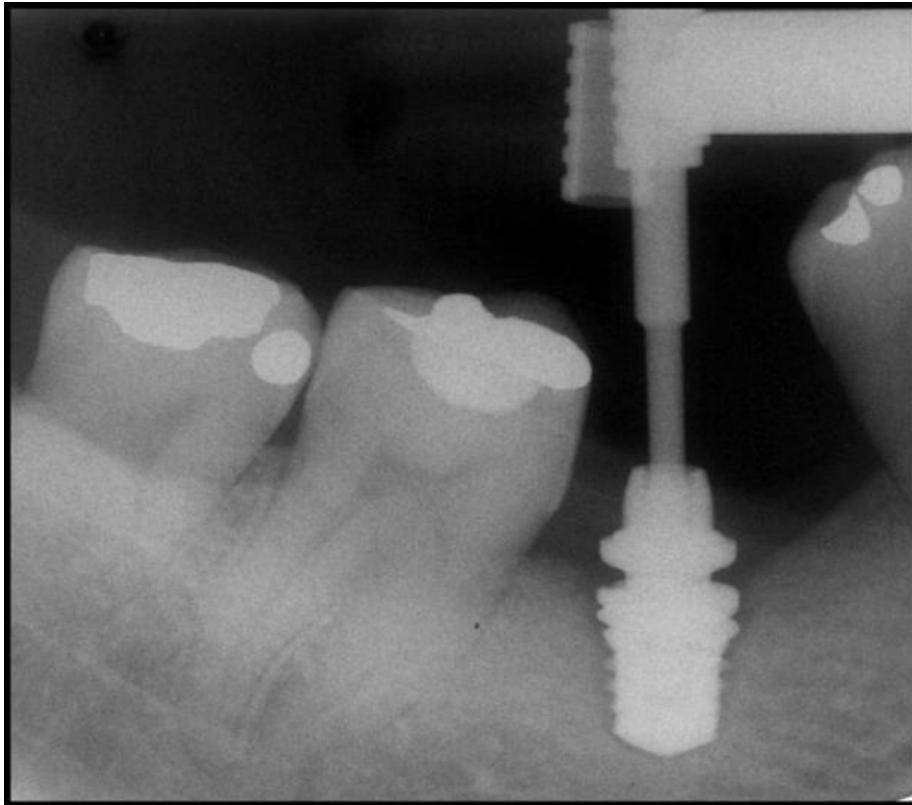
radiograph evidencing a radiolucent area surrounding the implant, characterizing non-osseointegration.
